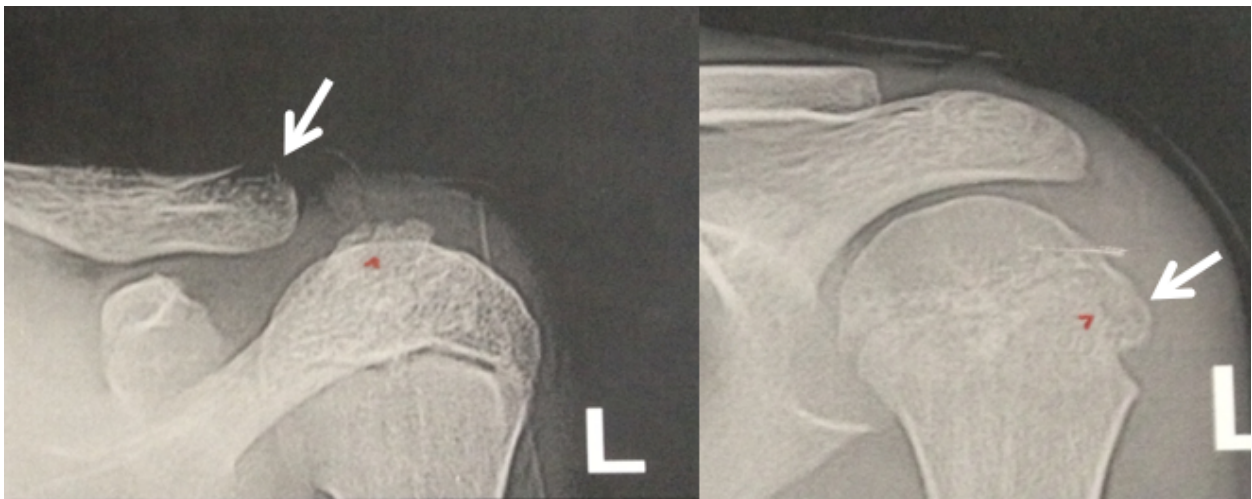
Left shoulder radiographs show bony outgrowths towards the posterolateral part of the collarbone, and in the outer region of the humeral head.
